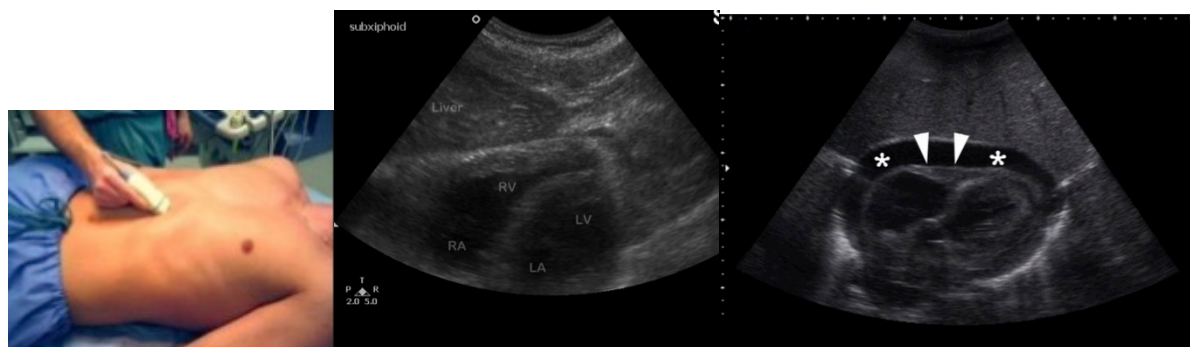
Examination of the substernal region. a: Proper positioning of the transducer in order to visualize the cardiac apex. b: Visualization of the cardiac apex and the ventricles in the ultrasonographic image. c: Ultrasonographic image of free fluid in the pericardium (*).
